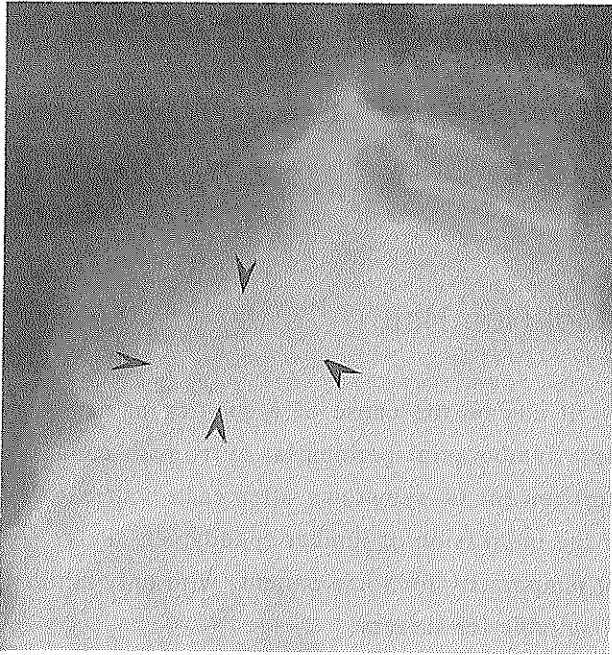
Plain film of lumbosacral spine revealing pressure erosion (arrowheads) of the sacrum.
